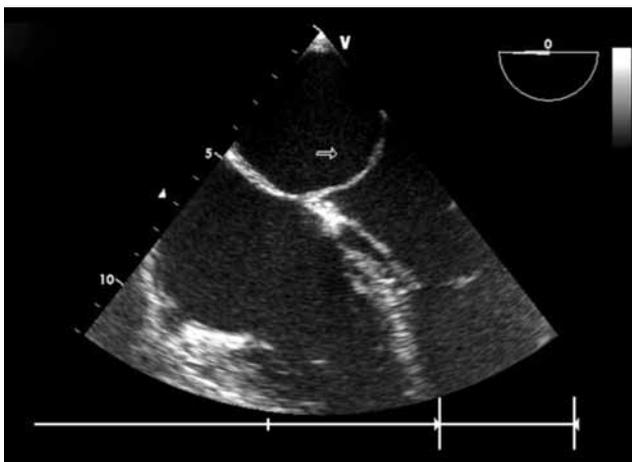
A transesophageal echocardiogram view reveals a linear echogenic density traversing the left atrium.
